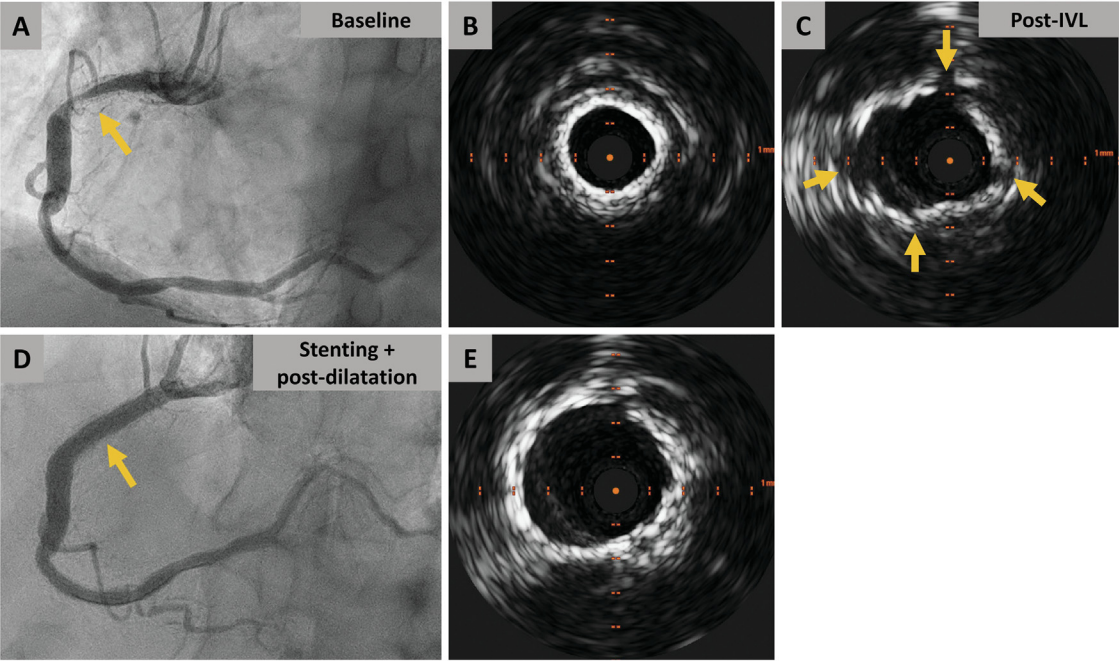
In-stent intravascular lithotripsy in severe in-stent restenosis because of calcified neoatherosclerosis. A: Baseline coronary angiogram showing severe in-stent restenosis at the proximal right coronary artery (RCA, arrow). B: Intravascular ultrasound (IVUS) demonstrating the presence of extensive (360 degrees) calcified neoatherosclerosis. C: IVUS post-IVL showing several fractures of the calcification (arrows). D: Angiogram after stenting and post-dilatation, showing excellent stent expansion (arrow) and confirmed by IVUS (E).
